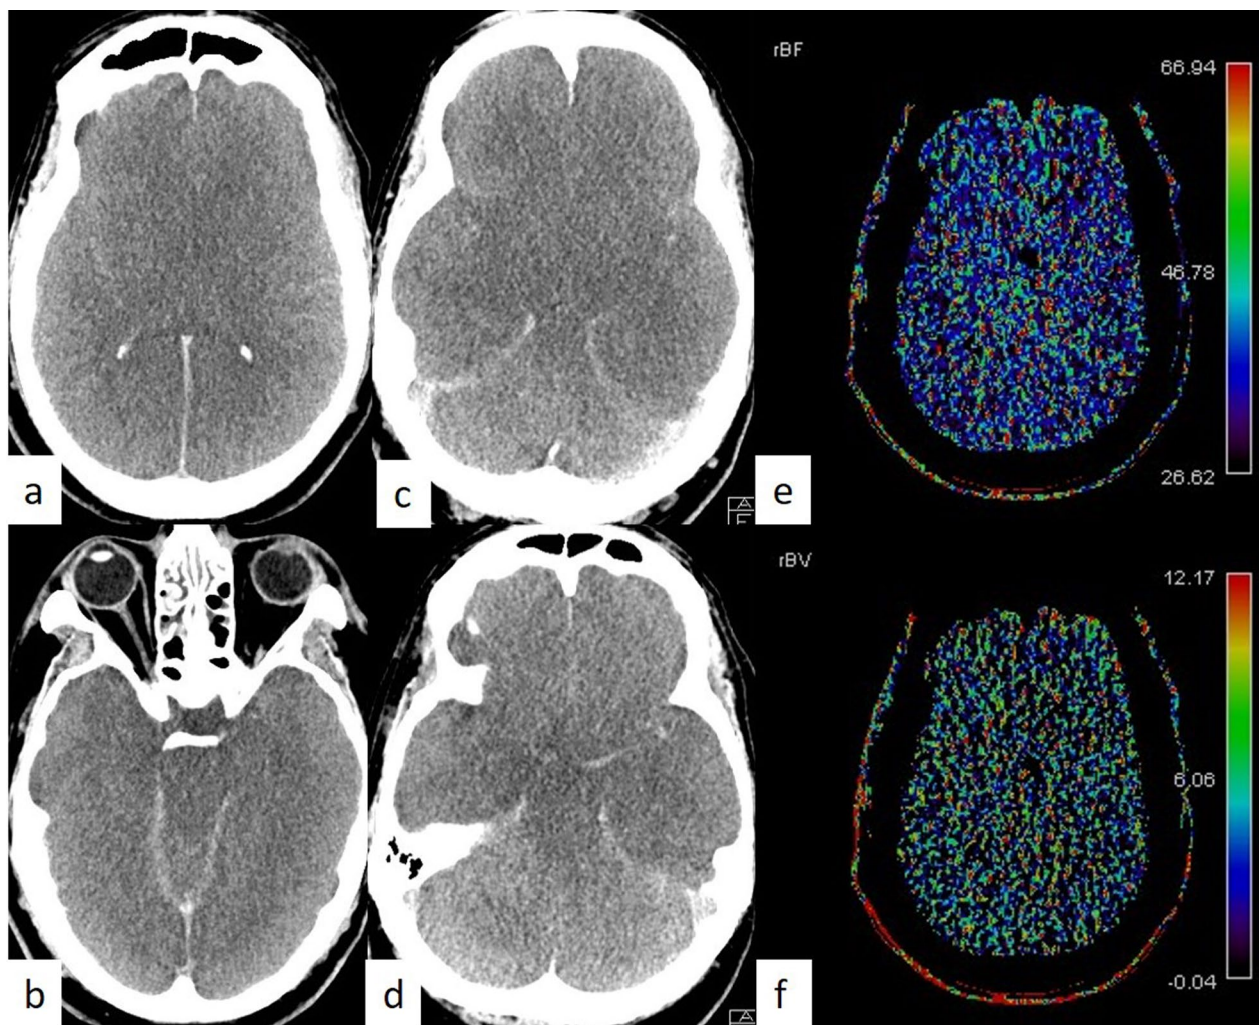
Non-contrast CT images of a comatose cardiac arrest patient in his 30 s showing diffuse loss of grey-white matter differentiation (a and b). CT angiogram showed only minimal filling of the proximal M1 branches of middle cerebral arteries (c and d), with no visible filling of the cortical branches of middle meningeal artery or any branches of anterior or posterior cerebral arteries. Coloured perfusion maps reveal markedly reduced or absent cerebral blood flow (e) and cerebral blood volume (f) consistent with CT perfusion findings of non-survival brain injury
